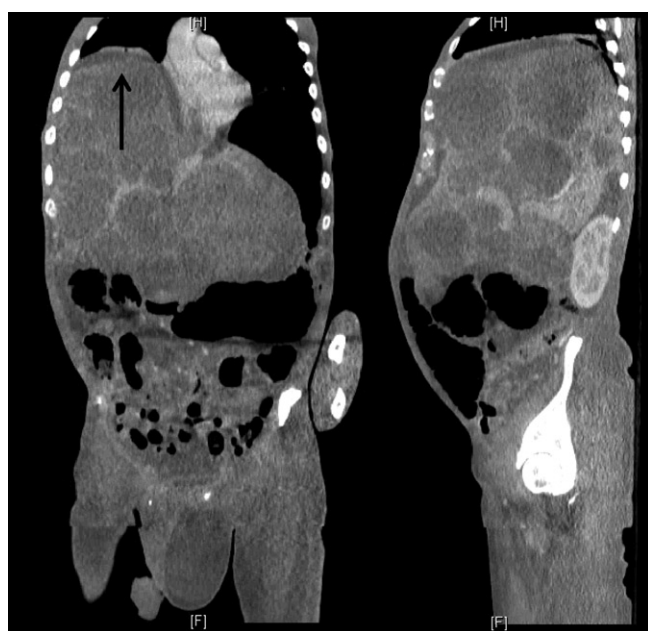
Coronal and sagittal views of computed tomography with contrast (single phase) of the abdomen reveal multiple hypoechoic hepatic lesions (arrow) causing elevation of the right hemidiaphragm and compression of the small bowel.
